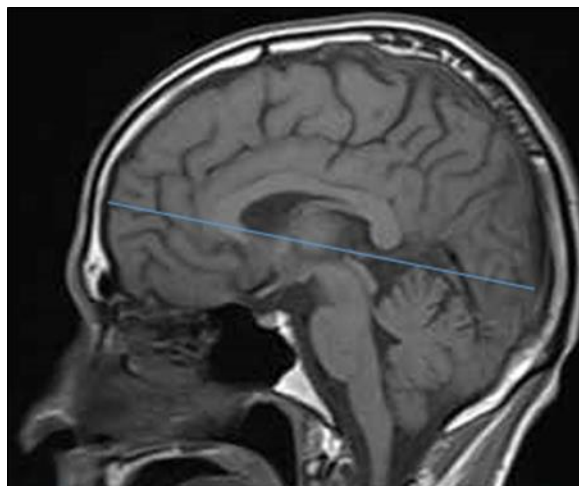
T1-sagittal section of MRI brain showing the measurement of the maximum AP diameter of the brain
